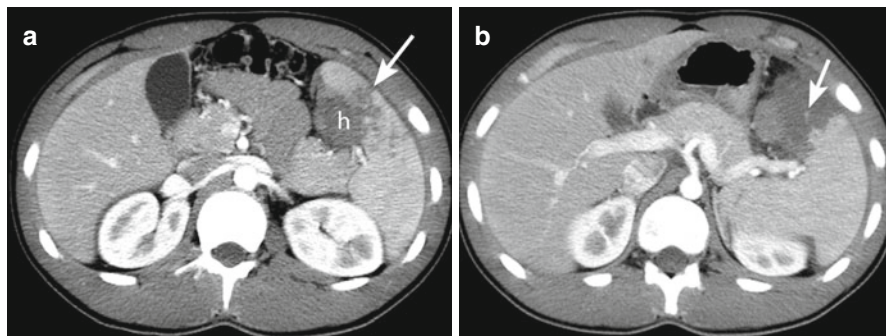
Spleen laceration and bleeding. (a) Contrast-enhanced computed tomography (CT) shows an irregular parenchymal defect (*arrow*) consistent with a laceration. Note the adjacent hematoma (*h*). (b) More superiorly, there is a small focus of active contrast extravasation (*arrow*) due to arterial hemorrhage
